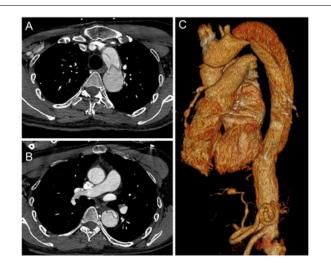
'Non-A Non-B' aortic dissection. Series of CT scan images showing a patient with a previous Bentall-De Bono surgery. A) New-on set'non-A non-B' aortic dissection with a large portal of entry located at the aortic arch. B) Prior graft tube at the ascending aorta and aortic dissection extending to the descending aorta. C) Three-dimensional reconstruction of the 'non-A non-B' aortic dissection.
